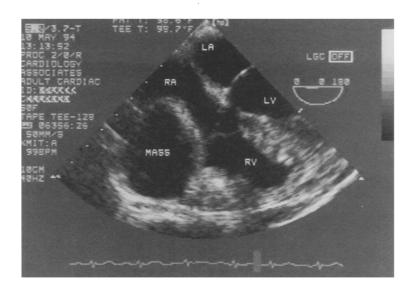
Transesophageal echocardiogram with multiplane probe in transverse plane. Right atrium (RA), right ventricle (RV), left atrium (LA), and left ventricle (LV) are shown. Adjacent to right heart is a large echolucent unilocular mass causing partial compression of RA.
